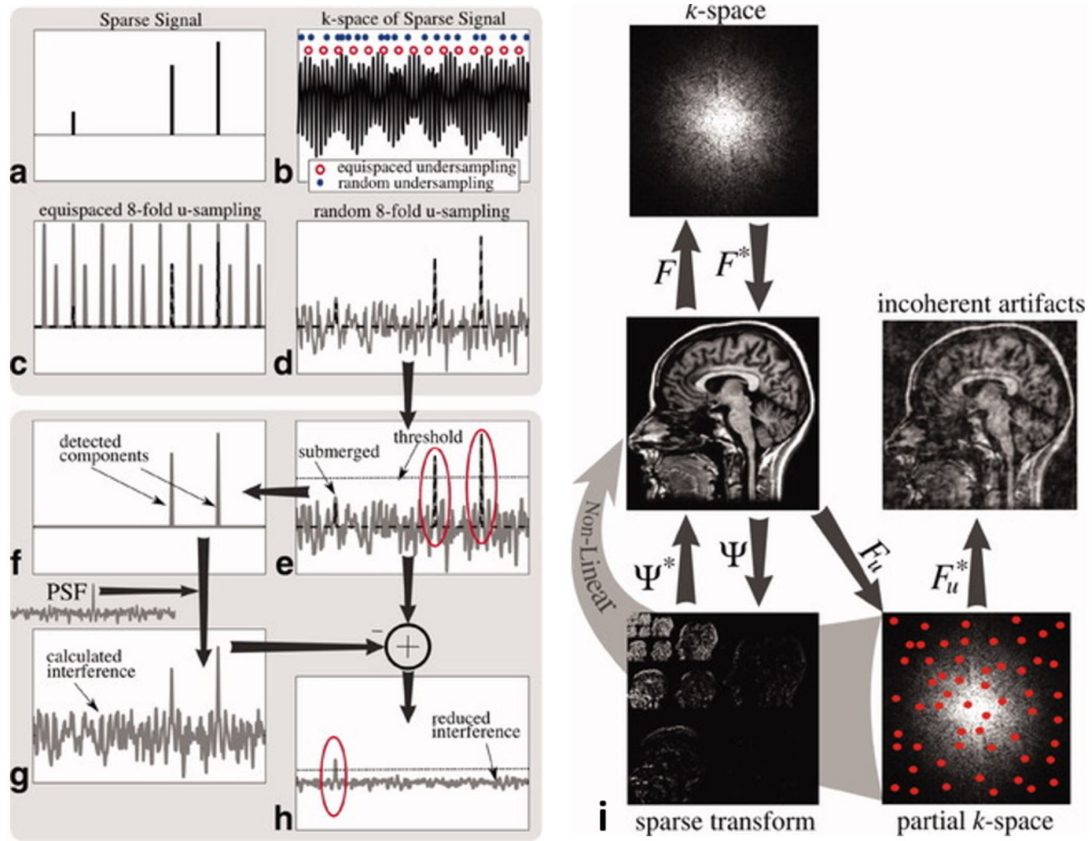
Basic idea of Compressed Sensing (16). Sparse signal with 3 non-zero elements (a) is the Fourier transform (FT) of a fully-sampled k-space data (b). If the k-space data in (b) is equally-spaced 8-fold undersampled (sample at red circles), the FT is aliased with 8 equally-spaced repeats of the 3 non-zero elements (c). The largest and smallest non-zero element in (a) are folded together in (c) and inseparable. If the k-space data in (b) is randomly 8-fold undersampled (sample at blue dots), the 3 non-zero elements are corrupted with incoherent noise-like aliasing (d). The two larger elements in d can be separated via thresholding (e, f). Corrupted signal of the two larger elements (g) are generated by undersampling the k-space of (f) at blue dots in (b). Signal with only the smallest element and its aliasing (h) can be obtained by subtracting (g) from (d). The smallest signal (h, red circle) can be separated from its aliasing with a threshold smaller than the threshold in (e). MRI image in (i) corrupted in random undersampling with incoherent artifacts can also be recovered with thresholding. The thresholding is applied in a sparse transform (Ψ) of the image. F and F^* : forward and inverse FT. F_u and F_u^* : forward and inverse FT with undersampling. Ψ and Ψ^* forward and inverse sparse transform.
